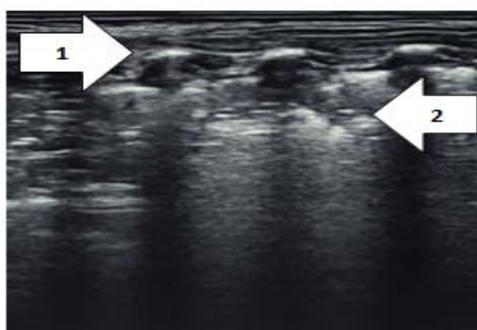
Chest ultrasound for MAS patient showing disrupted pleural line (Arrow 1), absent A lines, irregular consolidations with air bronchogram (Arrow 2).
